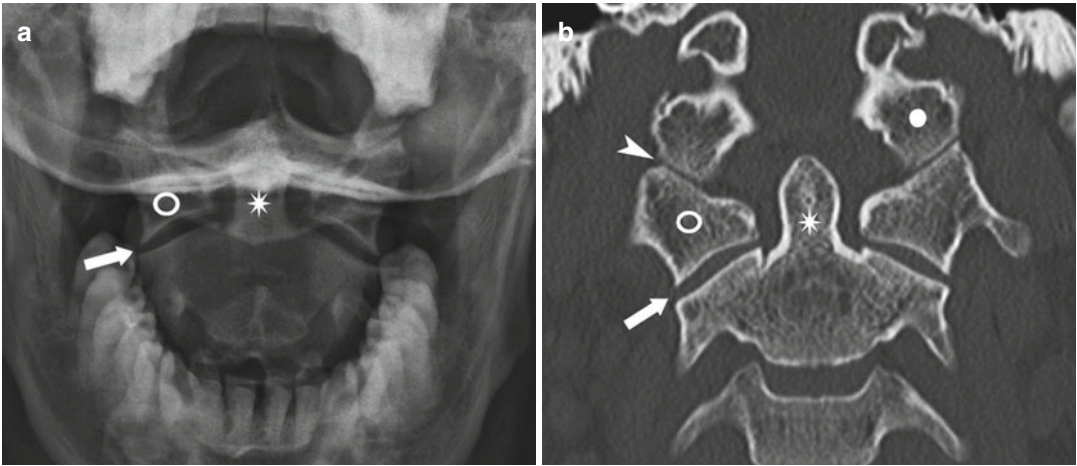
Cranio-vertebral junction (a) AP radiography for the examination of the dens of the epistropheus. (b) CT coronal reconstruction with bone algorithm, high resolution:
